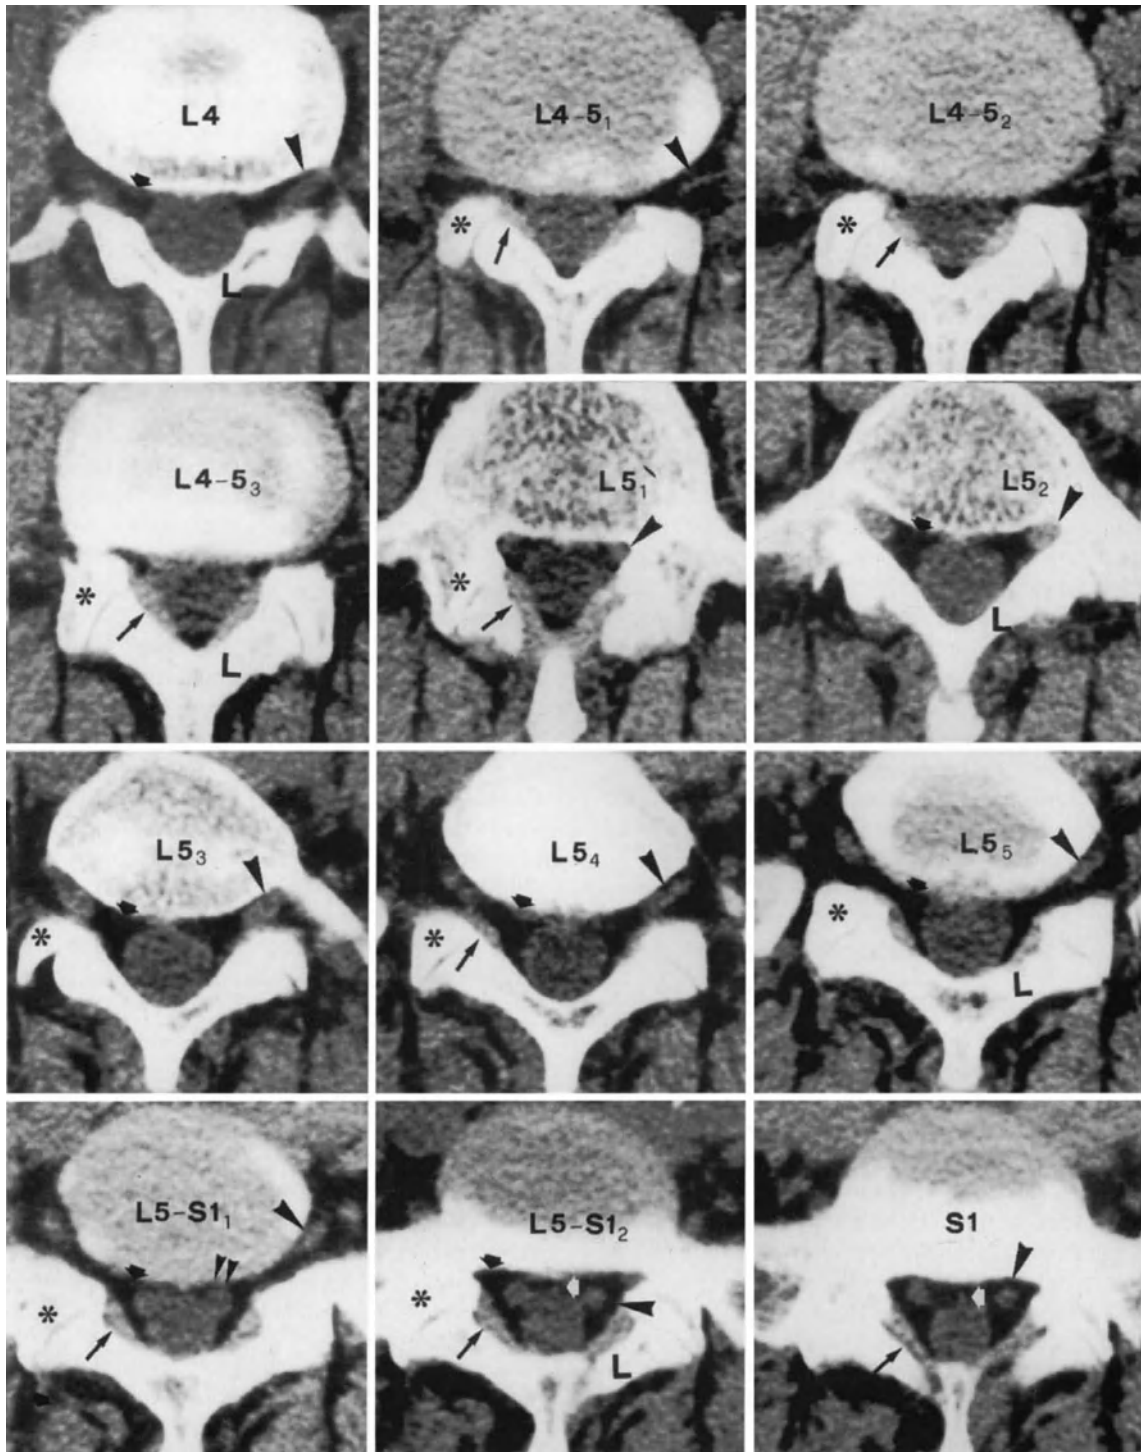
Sequential axial CT scans from the caudal half of L4 to the vertebral end-plate of S1. The arrowheads indicate the L4 nerve root in the L4-L5 intervertebral foramen (L4 and L4-5₁), the L5 root in the L5 radicular canal (L5₁ and L5₂) and L5-S1 intervertebral foramen (from L5₃ to L5-S1₁), and the S1 nerve root in the S1 radicular canal (L5-S1₂ and S1). The double arrowheads indicate the S1 root emerging from the thecal sac (L5-S1₁). The short black arrows indicate the epidural fat, which is typically hypodense, whilst the thecal sac shows the neutral density of the CSF. The asterisks are placed on the superior articular processes of L5 (from L4-5₁ to L5₁) and S1 (from L5₃ to L5-S1₂); the inferior articular processes are situated medially to the superior processes and are well visible at L5₁ (inferior articular processes of L4) and L5-S1₁ and L5-S1₂ (inferior articular processes of L5). The long black arrows indicate the ligamenta flava: the portion of the ligamentum located anteriorly to the facet joint can be seen at L4-5₁ and L5₄. The white arrow indicates the median meningovertbral ligament. Letter L indicates the laminae of L4 (from L4 to L4-5₃) and L5 (from L5₂ to L5-S1₂).
